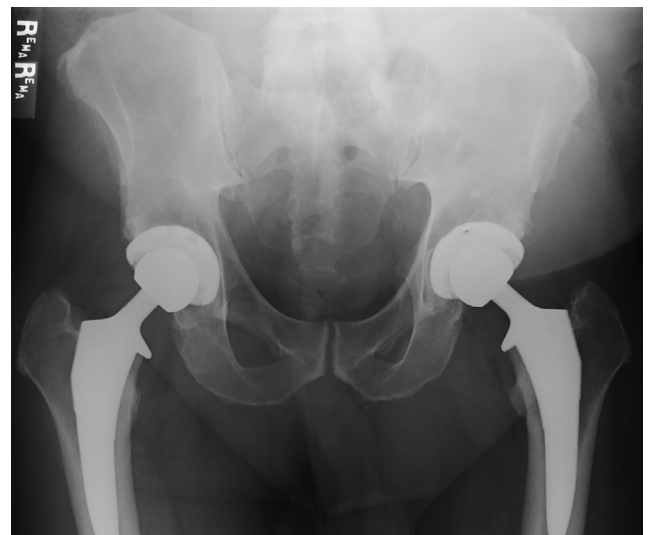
Case 1 postoperative antero-posterior pelvis radiograph demonstrating bilateral uncemented total hip arthroplasties.
